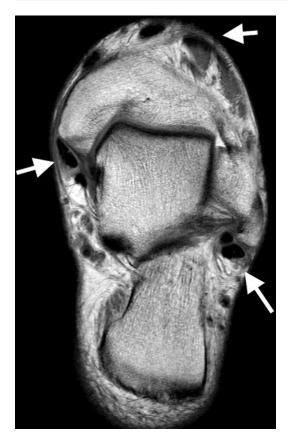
Axial oblique T2 MRI image of the ankle demonstrating multiple round and oval low signal intensity normal tendons (*arrows*)
